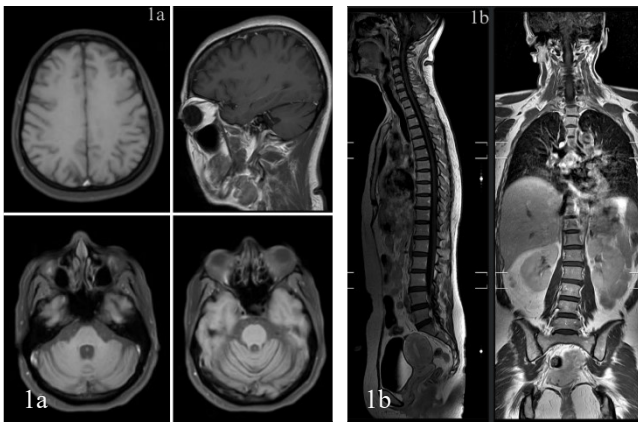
Brain contrast MRI findings: bilateral parietal lobes subacute lacunar infarction, bilateral frontoparietal lobes focal mild atrophy, not obtained brain stems and cerebellum atrophy, 1b. Whole spine contrast MRI findings: mild narrowing of the disc space C4-5 and C5-6, mild scoliosis of the lumbar, no visible pathological signal intensity in the spinal cord and bone marrow
